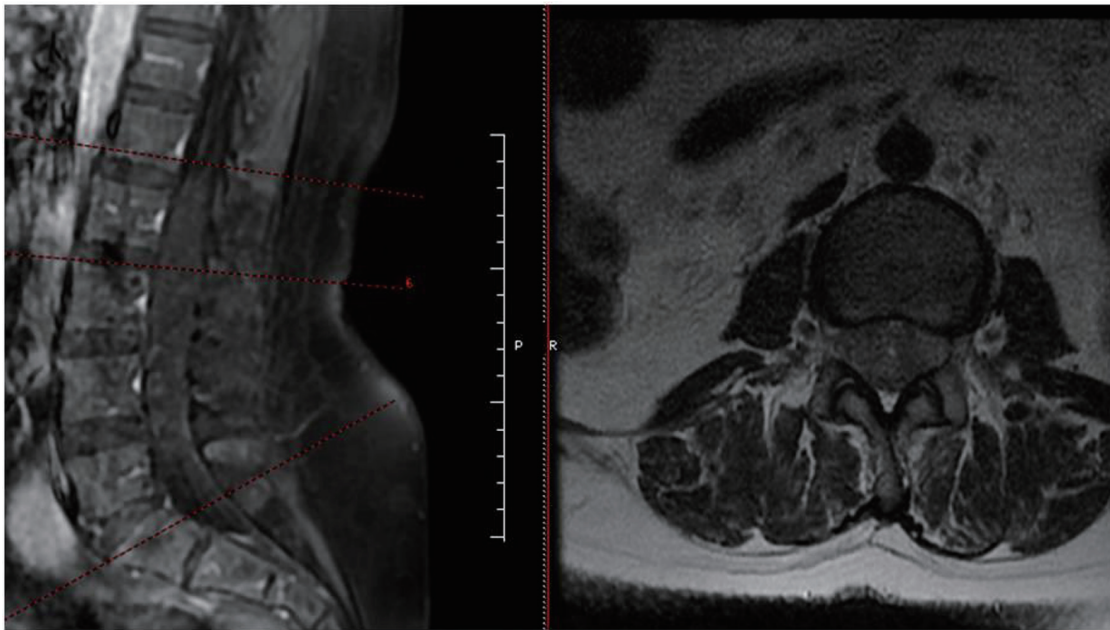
Preoperative T2-weighted lumbar MRI showing diffuse hypointense intradural appearance extending from the conus medullaris to the L4–L5 level. MRI: magnetic resonance imaging.
